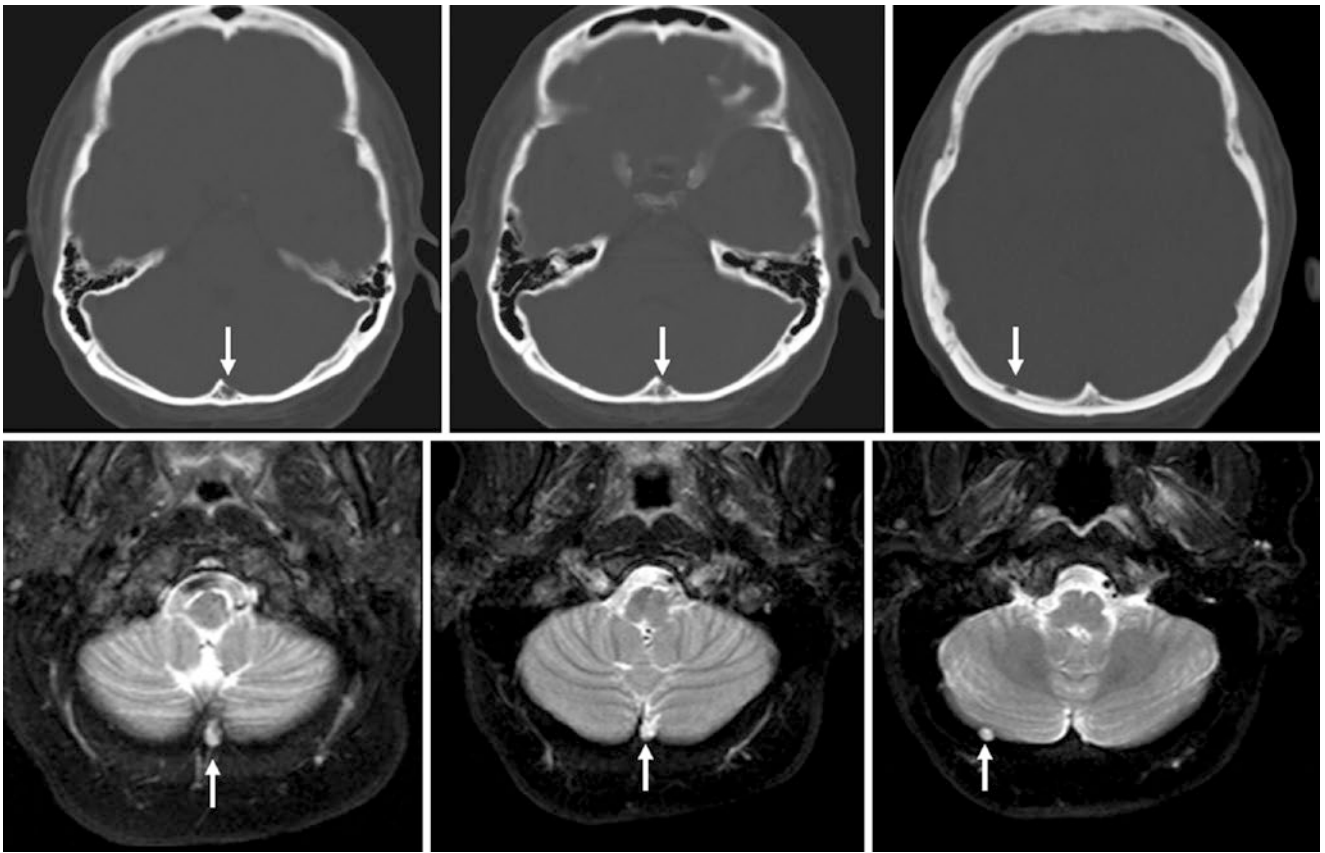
A 51 year old with two occipital pacchionian granulations on both axial NECT (*top row*) and T2WI MRI (*bottom row*). Each pacchionian granulation is adjacent to the dural venous sinuses
